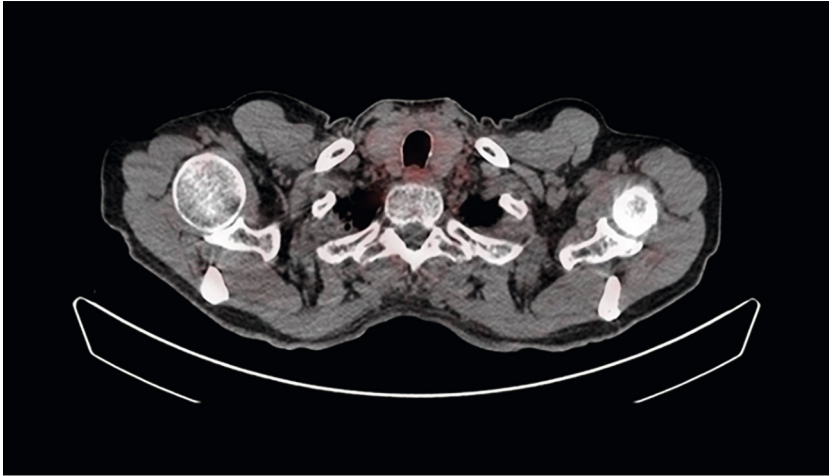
Thyroid without PSMA uptake on ^{68}Ga -PSMA PET/CT fused image.
